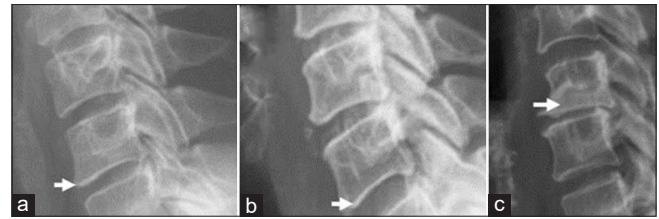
Lateral X-ray of cervical spine shows Endplate sclerosis; (a) The arrow points to the endplate, which appear normal, indicating the absence of the feature being graded. (b) The arrow points to the endplate, where sclerosis is present but not definitively clear. (c) The arrow points to the endplate, where sclerosis is definitively present
